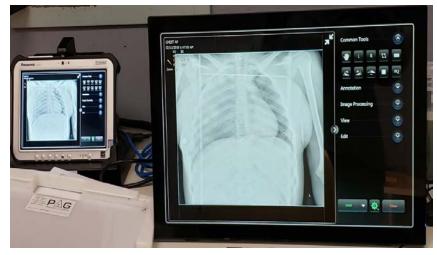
New X-Ray equipment
